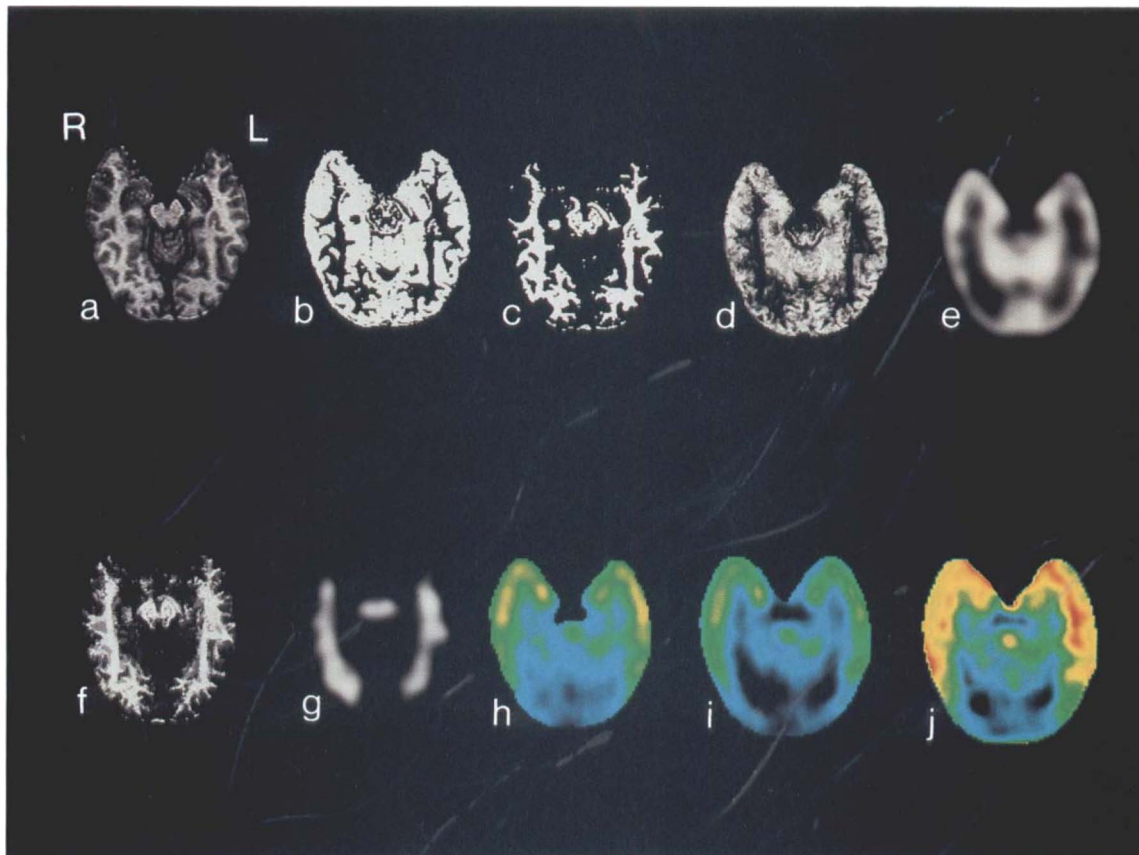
GM PET of μ opiate receptors in a patient with left-sided temporal lobe epilepsy using [^{11}C]carfentanil. Values in Fig. 8h-j are displayed to the same scale. (a) T_1 -weighted spoiled grass (SPGR) MRI image. (b) Segmented gray matter image. (c) Segmented white matter image. (d) Summed segmented gray matter images. (e) Convolved segmented gray matter images. Note that the density of gray matter tissue in the left anterior temporal lobe is lower compared to the right side. (f) Summed segmented white matter images. (g) Convolved segmented white matter images. (h) Observed PET image (I_{obs}). Symmetric distribution of [^{11}C]carfentanil binding to μ opiate receptors in temporal lobe. (i) PET image of the gray matter ($I_{\text{PET}_{\text{mod}}}$), obtained by subtracting the convolved weighted summed white matter image (Fig. 8g) from the observed PET image. (j) GM PET image (I_{gray}). Result of dividing $I_{\text{PET}_{\text{mod}}}$ by $I_{\text{MR}_{\text{mod}}}$. The image shows a global increase in the apparent tracer concentration. More importantly, [^{11}C]carfentanil binding to the left anterior temporal lobe is now higher when compared to the right anterior temporal lobe.
